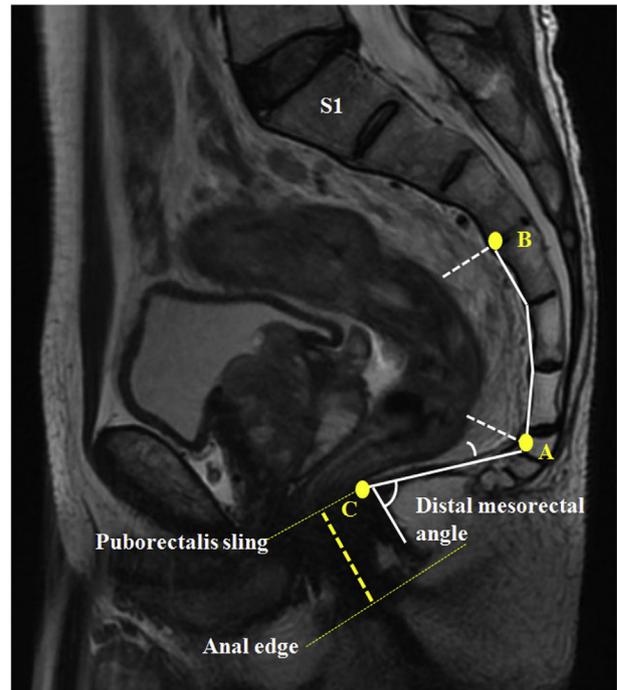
Variables measured on MRI. Line-sum length between point C to point A, and the length of point A to point B were recorded as the length of the posterior mesorectal fascia (white lines). The shortest line segment between point A/B and the posterior wall of the rectum was identified as the thickness of the posterior part of mesorectum (white dash lines). Distal mesorectal angle was identified as the angle between the posterior external sphincter muscle and the anococcygeal muscle (yellow arc).
